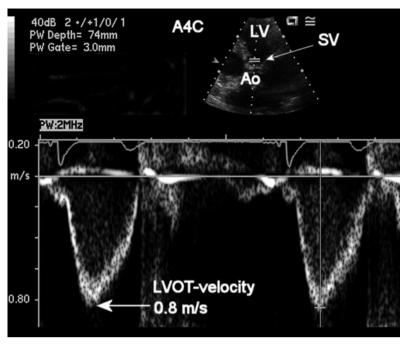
Left ventricular outflow tract (LVOT) velocity is measured from the apical approach either in an apical long-axis view or an anteriorly angulated four-chamber view (as shown here). Using pulsed-Doppler, the sample volume (SV), with a length (or gate) of 3–5 mm, is positioned on the LV side of the aortic valve, just proximal to the region of flow acceleration into the jet. An optimal signal shows a smooth velocity curve with a narrow velocity range at each time point. Maximum velocity is measured as shown. The VTI is measured by tracing the modal velocity (middle of the dense signal) for use in the continuity equation or calculation of stroke volume.
